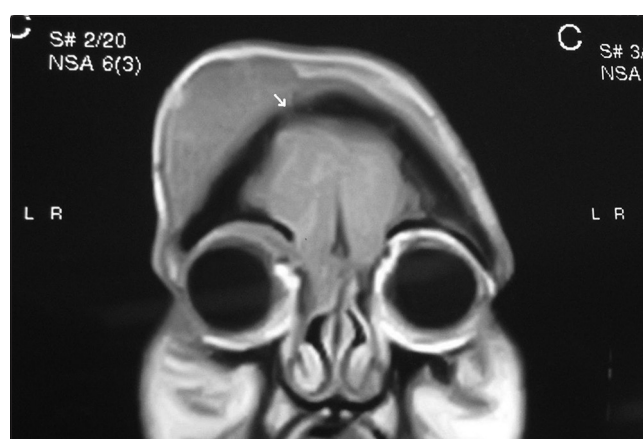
Magnetic resonance imaging of the brain showing a fairly large mass with mixed signal intensity involving the scalp of bifrontal supraorbital compartment with extension into the right orbit and right ethmoidal sinus through its anterosuperior part (marked with a white arrow)
